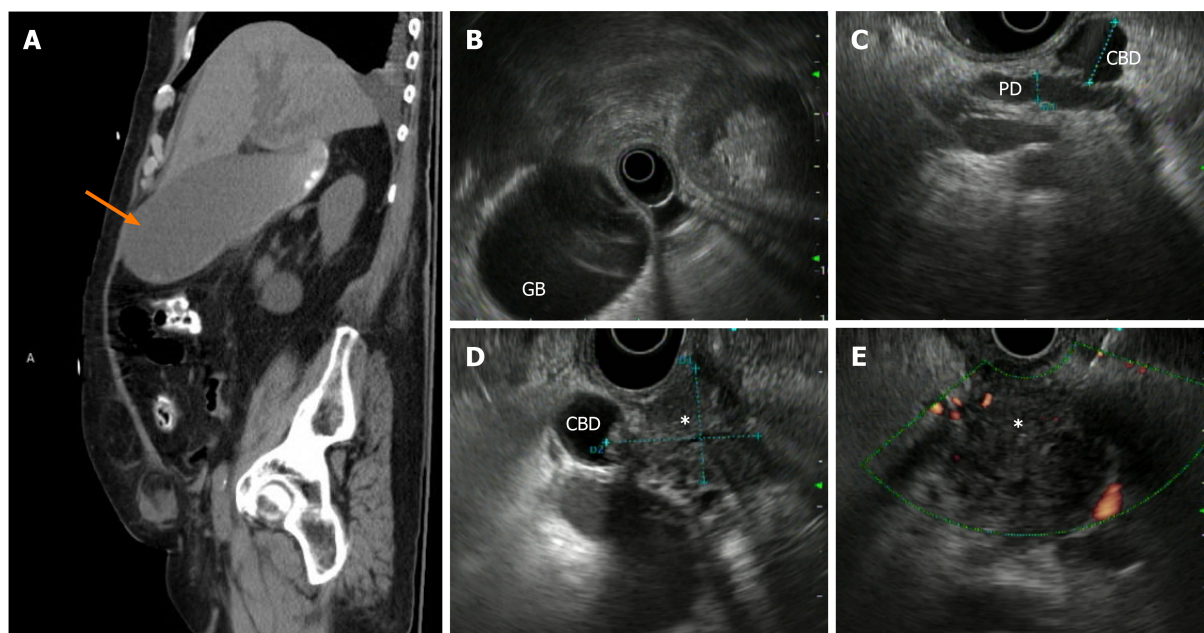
Endoscopic ultrasound in the diagnosis of obstructive jaundice. An 80-year-old male with a history of non-alcoholic fatty liver disease presented with new onset of painless jaundice, physical examination consistent with Courvoisier's sign (palpable gallbladder), and laboratory test results suggestive of severe biliary obstruction. A: Distended gallbladder (arrow) seen on computed tomography, sagittal view. B: Distended gallbladder seen on endoscopic ultrasound. C: Double duct sign consisting of a dilated common bile duct (CBD) and dilated pancreatic duct. D: A poorly-margined, hypoechoic pancreatic mass (asterisk) invading the distal CBD. E: Fine-needle biopsy of the pancreatic mass (asterisk), which led to tissue diagnosis of adenocarcinoma and facilitated subsequent management. GB: Gallbladder; PD: Pancreatic duct; CBD: Common bile duct.
